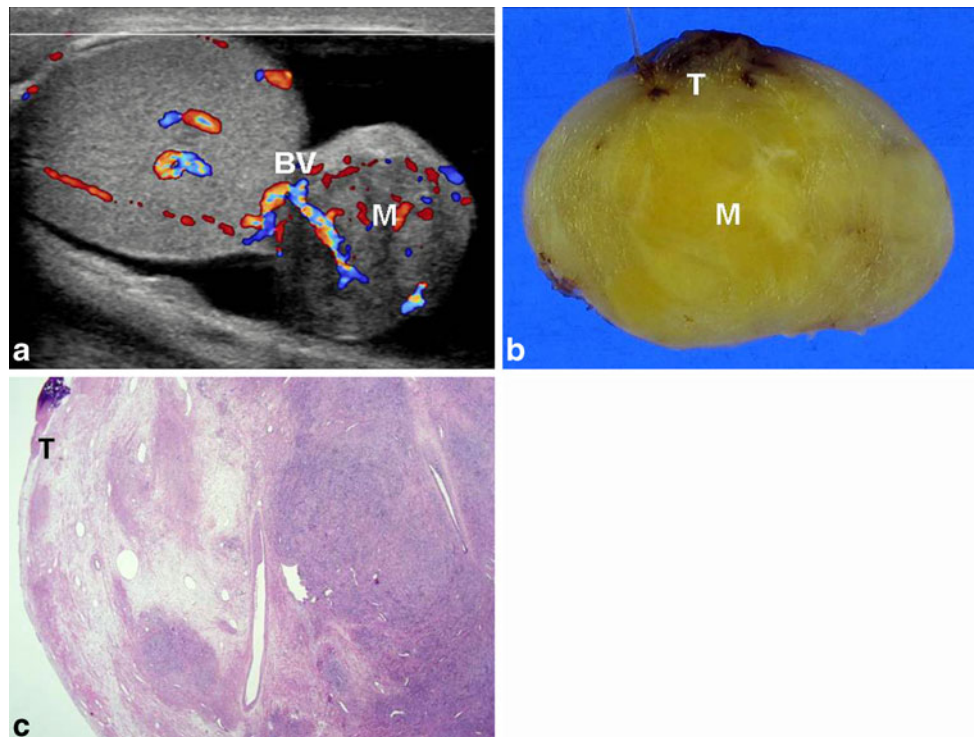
A 31-year-old man with paratesticular leiomyoma suffered from a left scrotal palpable lesion. a Colour Doppler US of the left testis shows heterogeneous hypoechoic bulging nature mass (M), which presented with vascularity and a penetrating or bridging vessel (BV) between the left testis and abutting mass (M). The whirling pattern and multiple narrow areas of shadowing within the mass are suspicious for leiomyoma. Radiologic primary diagnosis was a tumor
